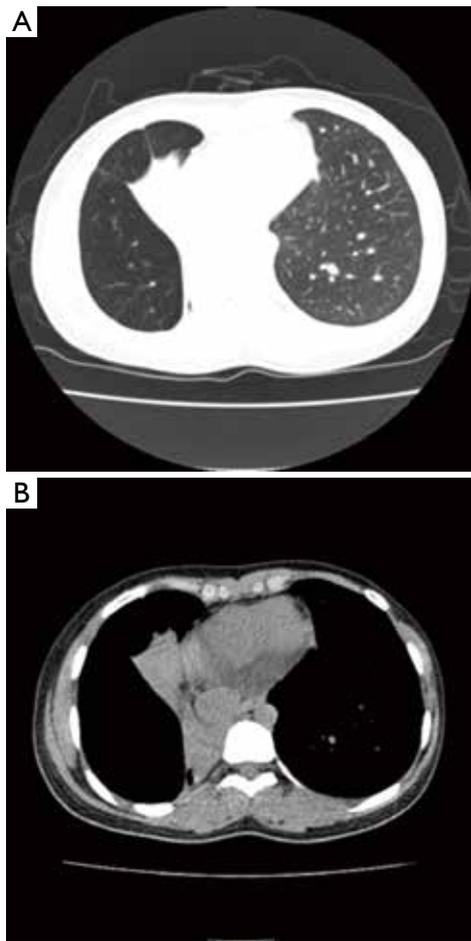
Chest CT shows right middle lobe atelectasis. (A) Lung window; (B) Mediastinal window.
